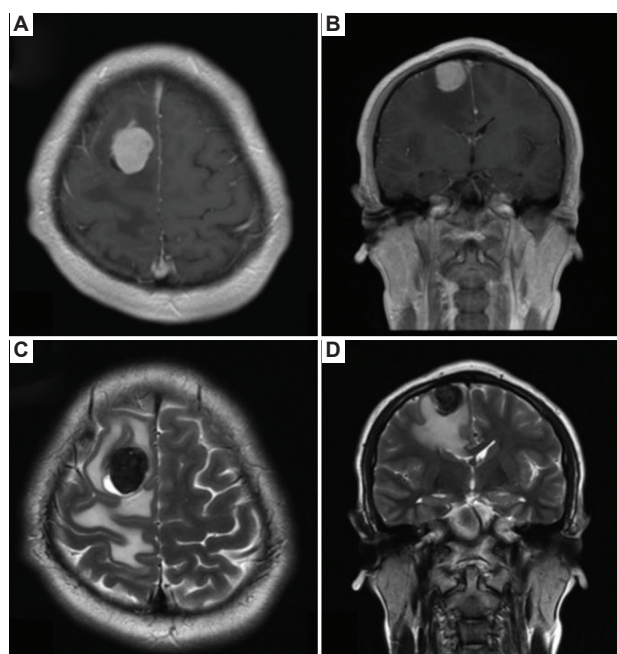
Magnetic resonance imaging of intracranial melanoma in an adolescent in the right parasagittal frontal region, surrounded by vasogenic edema. (A) Tumor mass enhancing with contrast on axial. (B) Tumor mass enhancing with contrast on coronal T1-weighted images. (C) Cystic component in the tumor mass on axial. (D) Cystic component in the tumor mass on coronal T2-weighted images. Adapted from Golden *et al.*²⁷
